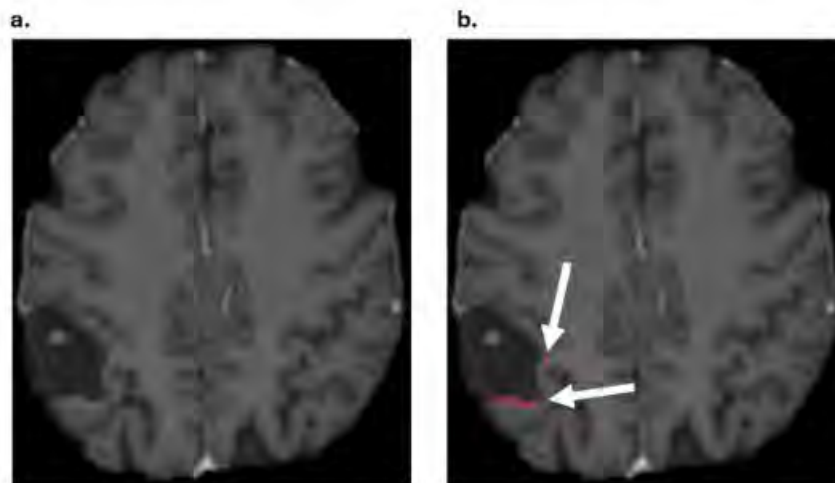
Example of false positive classification of disease progression. (a) Postoperative MRI showing smooth postsurgical enhancement along the margins of the resection cavity. (b) Incorrect segmentation of the enhancement as new lesions, leading to incorrect classification as “Progressive Disease”.
